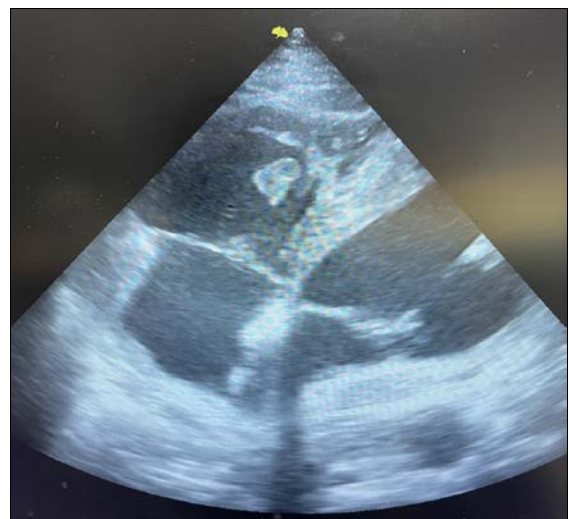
Transthoracic echocardiogram showing the thrombus in the right ventricle
